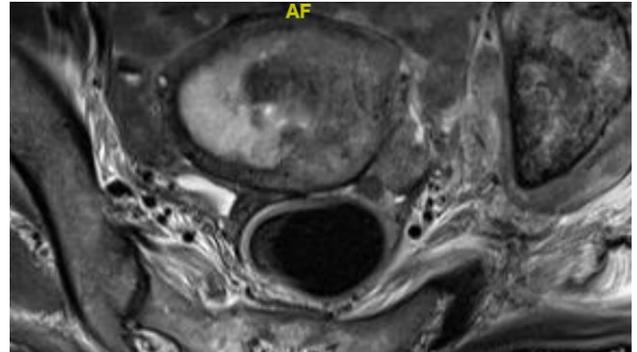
MRI Pelvis (axial view)
